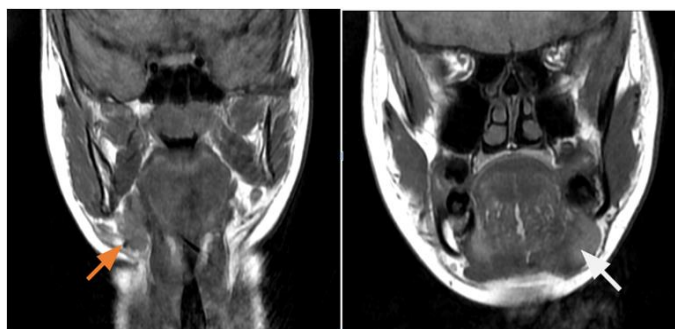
(A, B) Coronal T1W MRI images showing hypertrophied right sublingual gland (orange arrow) extending into the right submandibular area and hypertrophied left sublingual gland (white arrow) herniating through ipsilateral anterior mylohyoid muscular defect.
